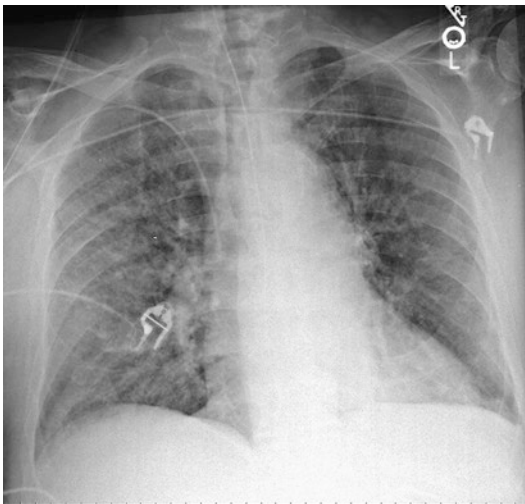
Bilateral infiltrates on chest radiograph
